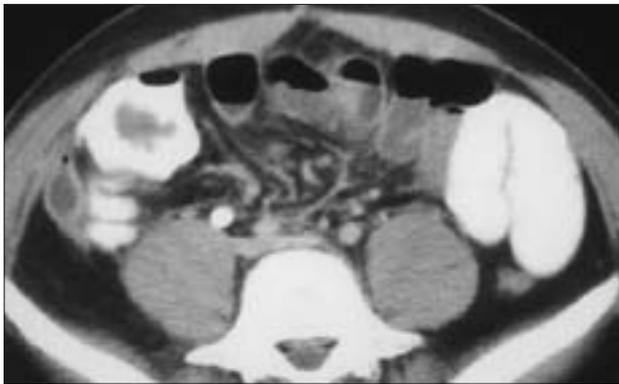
On axial CT image, the dilated lumen of the appendix is filled with fluid and shows thickened and enhanced walls after intravenous contrast medium administration.
